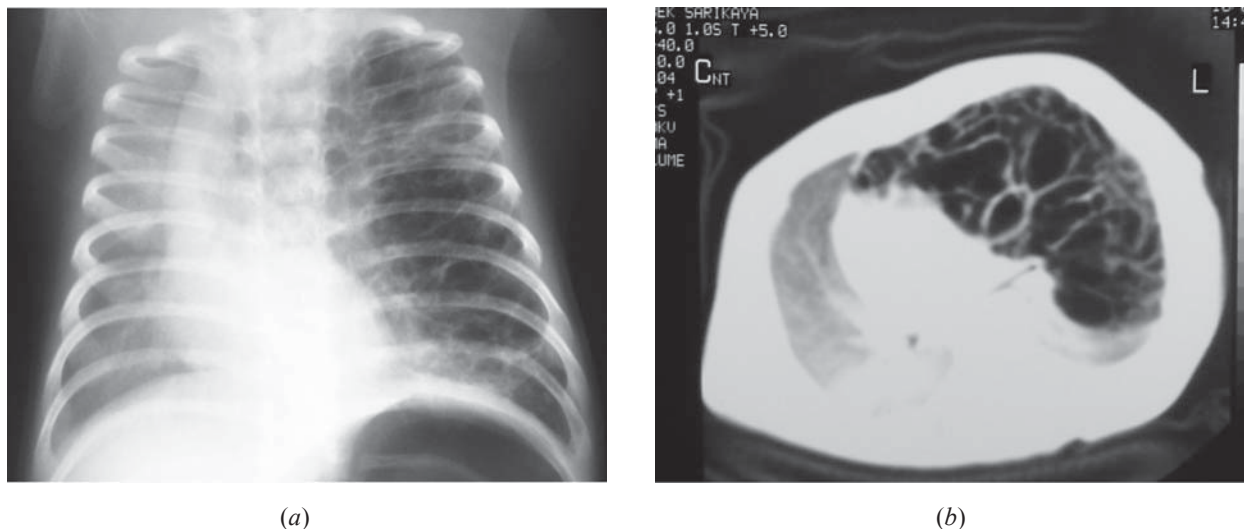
(a) Diffuse cystic changes in the left lung. (b) Thoracic CT revealed multiple cysts of varying sizes occupying the entire of the left upper lobe, atelectasis in the left lower lobe and a mediastinal shift to the right.
